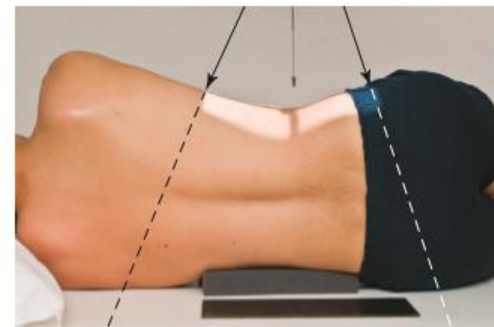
Close four-sided collimation. The collimated light field may appear too small because of divergence of x-rays.
